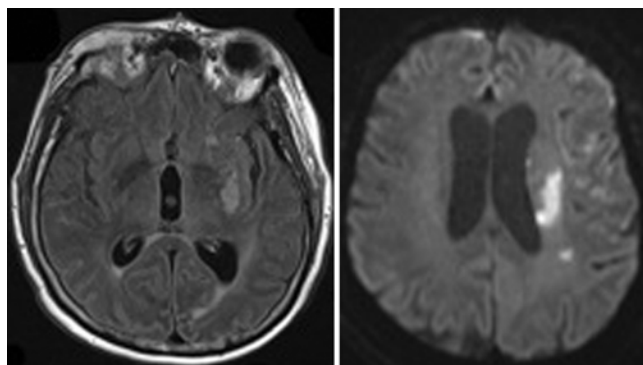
Postoperative follow-up axial FLAIR (left) and diffusion-weighted (right) MR imaging. The FLAIR image reveals a small area of signal hyperintensity in the left basal ganglia representing the final infarct core. The diffusion-weighted image shows a small area of acute restriction in the left periventricular subcortical white matter.
